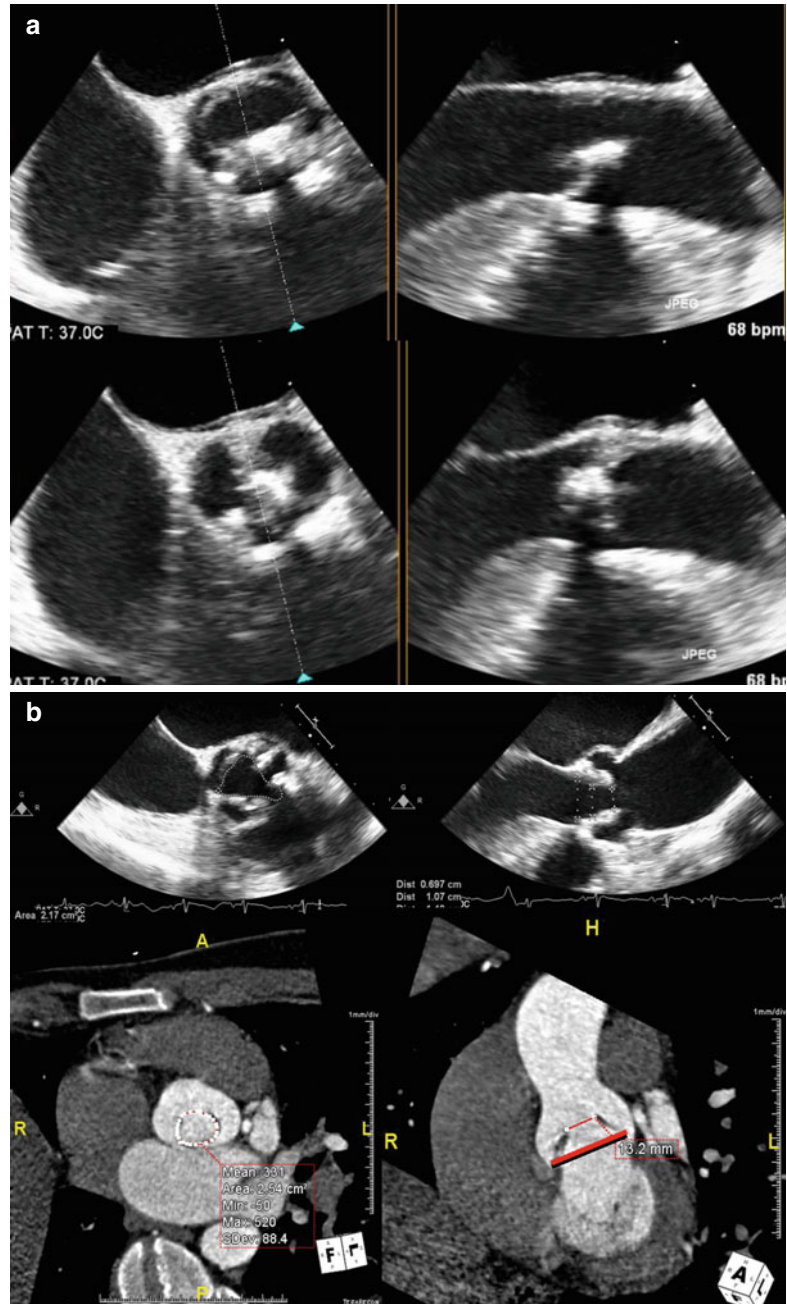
Congenital unicuspid (a) and bicuspid valves (b) noted on echocardiography. The right cusp and non-coronary cusps are fused. (c) Demonstrates a calcified bicuspid aortic valve noted on CTA
